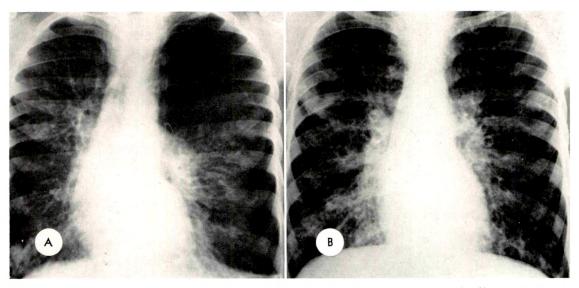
(A) Pneumothorax in a 12½ year old male with severe respiratory involvement by fibrocystic disease A thoracotomy tube was inserted, with water-seal suction, and a subsequent roentgenogram (B) shows no further air in the pleural cavity.
